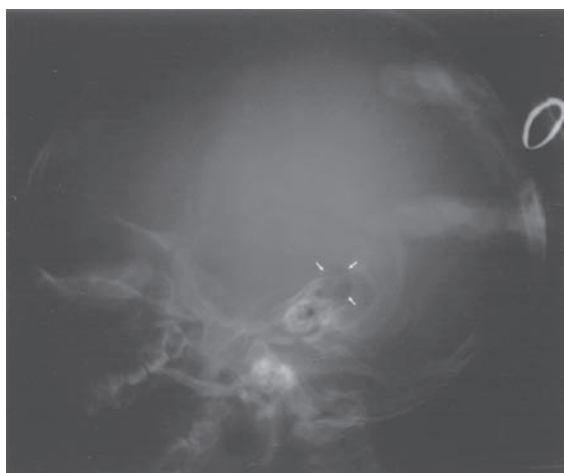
Lateral skull X-ray (Schüller) demonstrating histiocytosis X in right temporal bone (with arrows).
